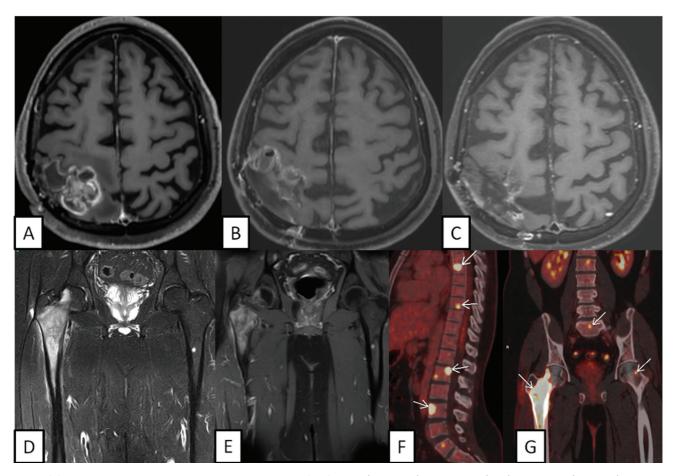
(A) Presurgery contrast T1 magnetic resonance imaging (MRI) in October 2020—heterogeneously enhancing mass lesion with necrotic areas seen involving the right parietal lobe region favoring high-grade glioma likely grade 4 astrocytoma. (B) Postsurgery contrast T1 MRI November 2020—complete excision of the mass lesion with postoperative changes seen. (C) Recent contrast T1 MRI—no significant residual or recurrent tumor mass seen. (D) (Short-tau inversion recovery [STIR] coronal sequence MRI) STIR hyperintense large mass lesion seen at right proximal femur. (E) T1 postcontrast T1 fat saturated (FS) showing heterogeneously enhancing lesion at right proximal femur. Small lesion at left femur shaft. (F) Multiple fluorodeoxyglucose (FDG) avid lesions in positron emission tomography-computed tomography (PET-CT) at dorso-lumbar vertebra. (G) Multiple FDG avid lesions in PET-CT in bilateral proximal femur.
